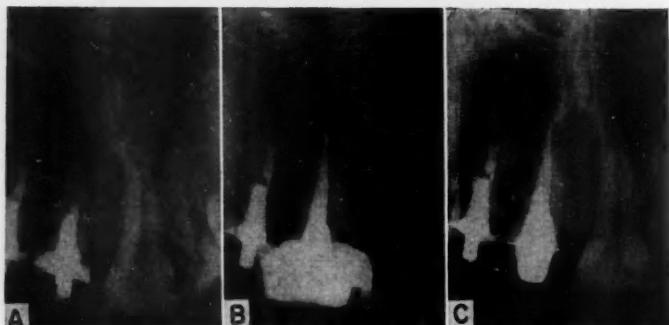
Maxillary incisor showing periapical bone involvement. Note poor root filling and the presence of a metal post. A, Before re-treatment; B, after re-treatment; C, 10 years after treatment.
